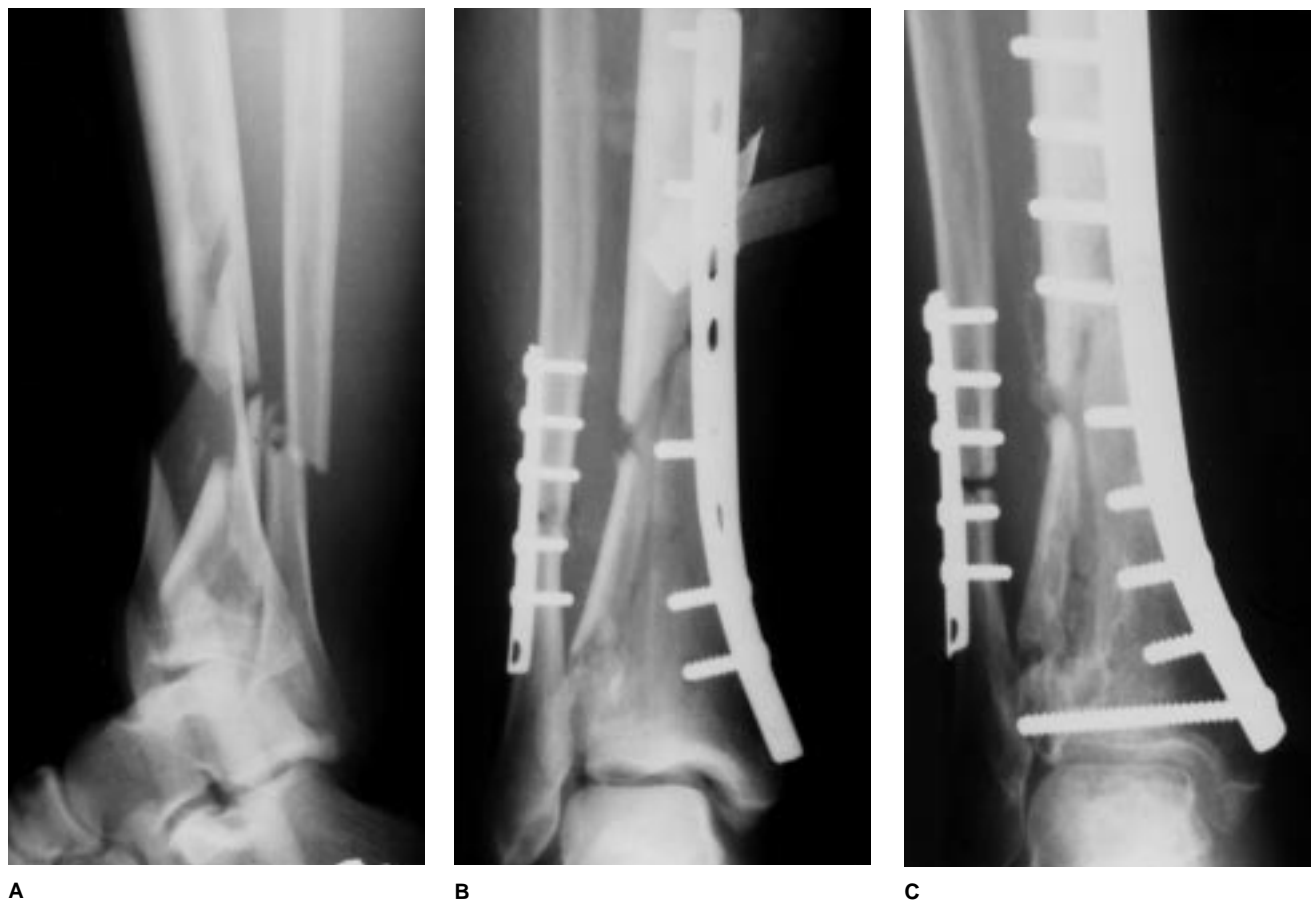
A, Radiograph of a comminuted distal-third tibial-fibular fracture. B, Intraoperative radiograph shows reduction with use of a precontoured narrow 4.5-mm dynamic compression plate. Lateral fragment was teased into place without disrupting soft-tissue attachments. C, Radiograph obtained 6 months after open reduction and internal fixation shows incorporation of the lateral fragment, which healed without bone grafting.
